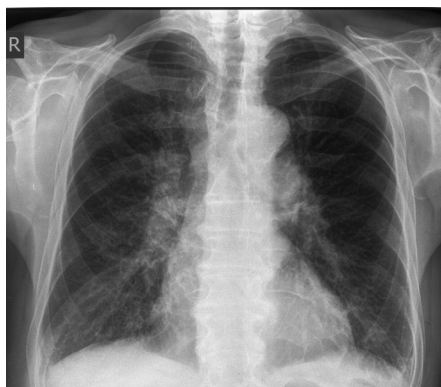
Chest x-ray shows enlarged cardiac silhouette and prominent hilum bilateral.
